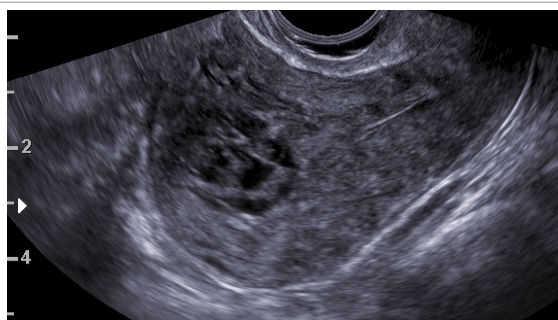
Transvaginal sonographic longitudinal section of the uterine corpus, showing the presence of an inhomogeneous mass located in the anterior uterine wall.
